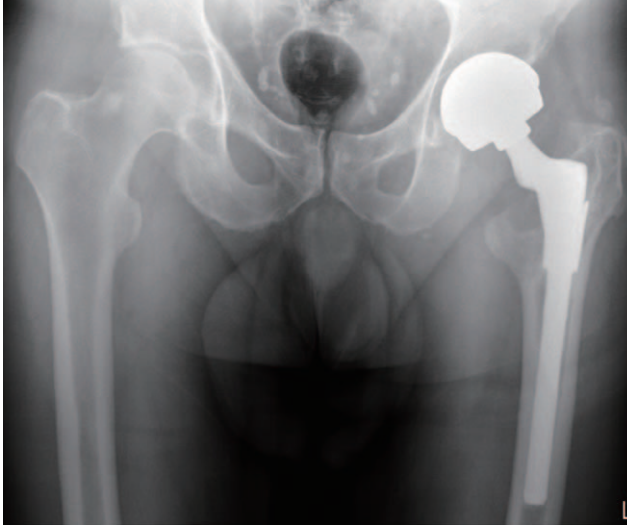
Anteroposterior pelvis x-ray at time of acute presentation with hip pain and sepsis. S-ROM femoral components (DePuy Orthopaedics, Warsaw, IN, USA) with metal on metal bearing. The proximal femoral erosion around the lesser trochanter was longstanding and unchanged in size over many years.
